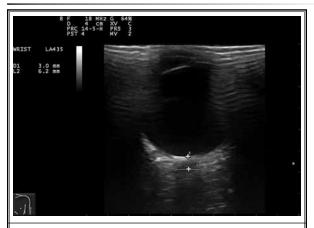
Ultrasound image of the optic nerve sheath diameter (ONSD) evaluation. ONSD is measured 3 mm posterior to the glob of the eye.
